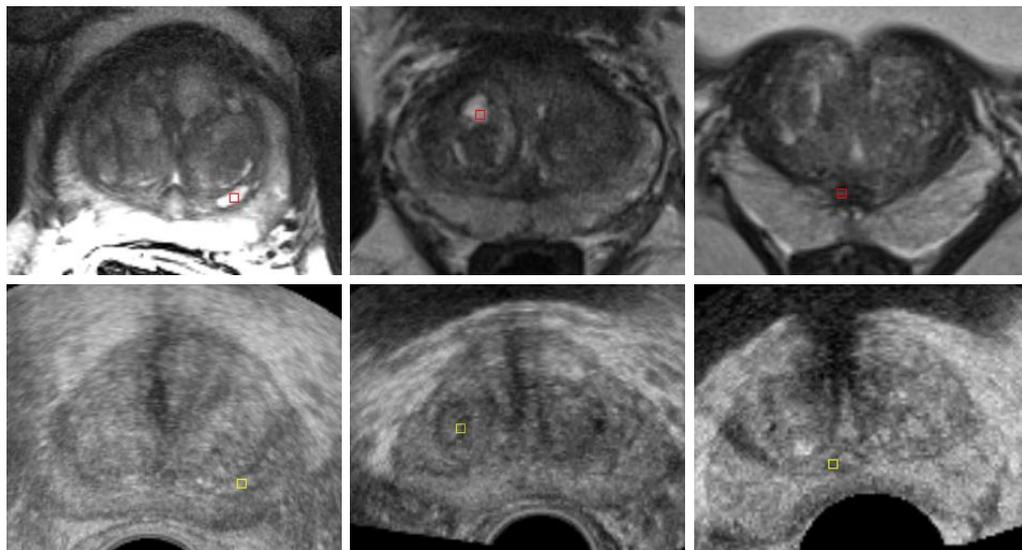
Some examples of anatomical reference landmark points. The three columns show reference landmarks in the corresponding MR images (top row) and TRUS images (bottom row) of three different patients.
